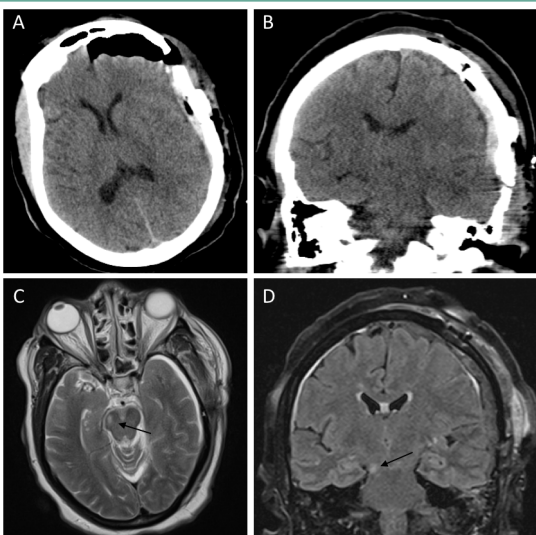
Axial (A) and coronal (B) CT of the head following left-sided craniotomy for evacuation of SDH. Axial T2-weighted (C) and coronal FLAIR (D) MRI obtained 6 days after injury demonstrates hyperintensity within the right cerebral peduncle (arrow).
